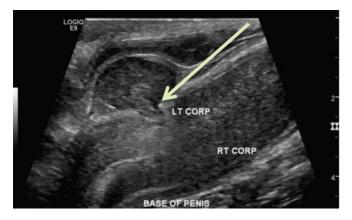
Focal defect along the dorsal tunica albuginea with herniation of a portion of the corpora cavernosa (arrow), consistent with penile fracture. LT CORP = left corpus cavernosa; RT CORP = right corpus cavernosa. Adapted from Figure 9 of McAdams CR, Del Gaizo AJ. The utility of scrotal ultrasonography in the emergent setting: beyond epididymitis versus torsion. *Emerg Radiol.* 2018;33(1):721. doi:10.1007/s10140-018-1606-y.
